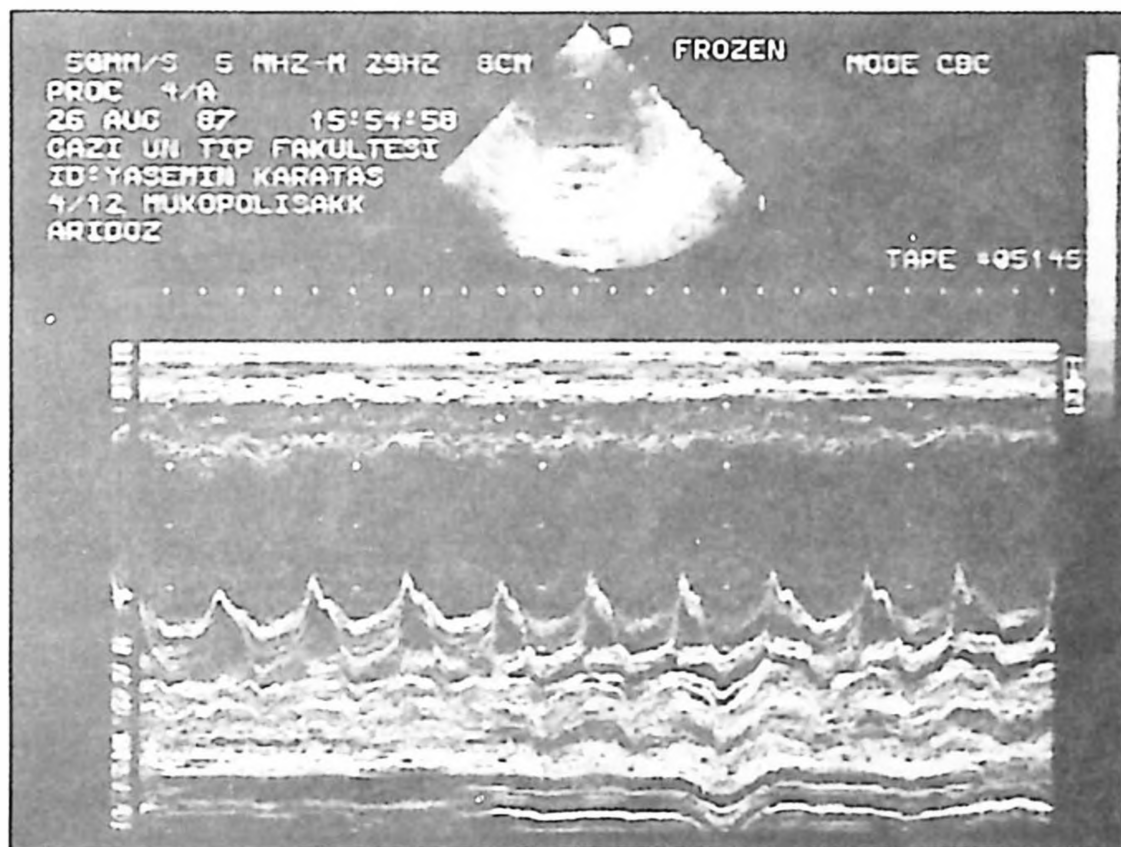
Echocardiogram shows mitral valve prolapse.
